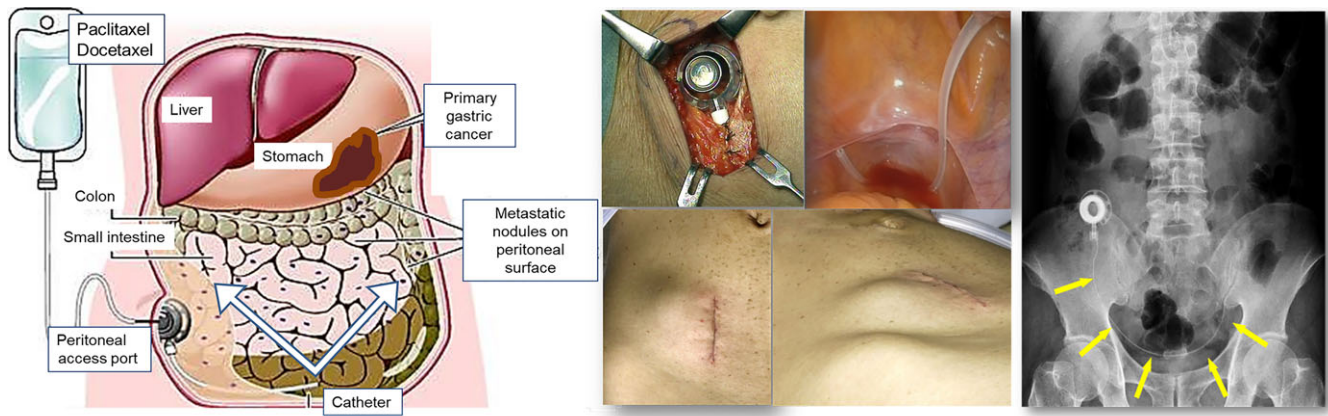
Left: Repeated intraperitoneal chemotherapy using an implantable port system. The catheter is placed in the pouch of Douglas (arrows) and taxanes dissolved in 500–1000 mL saline infused over 60 min. Right: Representative laparoscopic and X-ray views of intraperitoneal port and catheter
